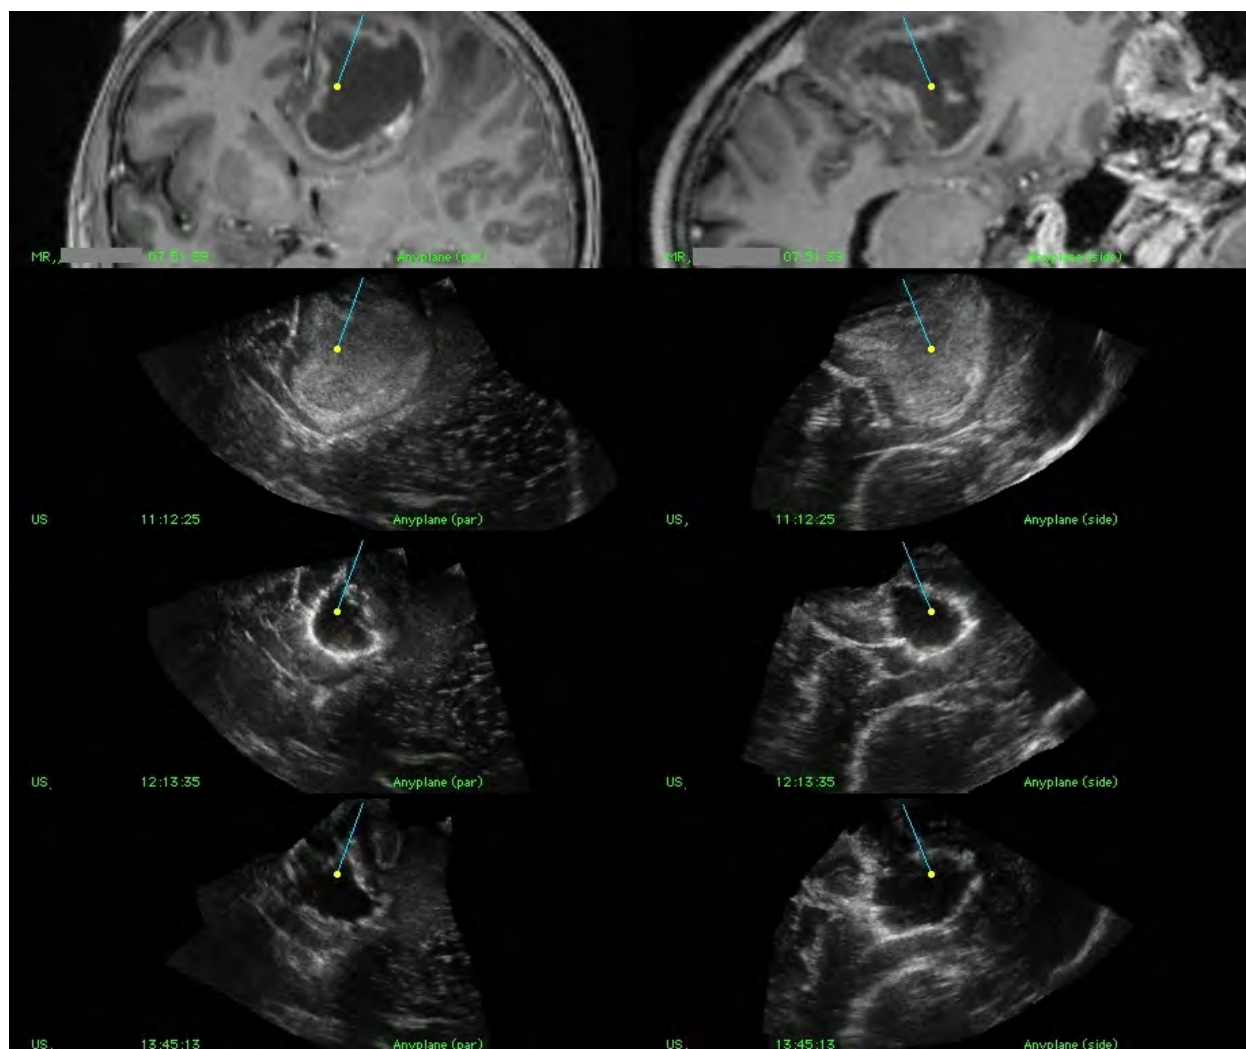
Navigation display showing two perpendicular reformatted image slices from each image volume. Preoperative MR slices in top row followed by slices from 3 different ultrasound volumes acquired at different stages in the operation. The ultrasound volumes in row 2, 3, and 4 were acquired prior to the resection, during the resection with some tumor tissue remaining, and after the end of the resection, respectively
